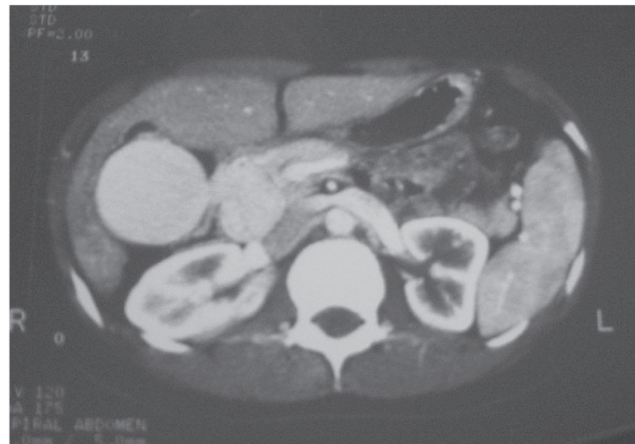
Computed tomography showing the portal vein aneurysm with high signal similar to that of the aorta and the inferior vena cava and no significant change in size and shape. Performed in 2005.
